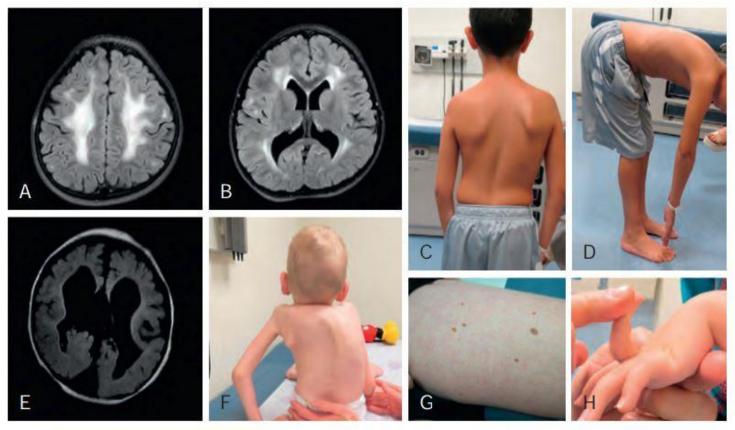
Findings in congenital muscular dystrophies. A and B, Axial FLAIR brain MRI images showing the increased T2 hyperintensity seen within the white matter in patients with LAMA2 CMD. C, Scapular winging and scoliosis in patient with SEPN1 muscular dystrophy. D, Rigid spine noted in forward flexion in patient with SEPN1 muscular dystrophy. E, Brain MRI in patient with muscle-eye-brain disease with absent corpus callosum, Dandy-Walker malformation, subependymal cysts. F, Early and severe kyphoscoliosis in a child with Ullrich congenital muscular dystrophy. G, Keratosis pilaris, a common skin finding in patients with collagen VI-related CMDs. H, Distal hyperlaxity seen in patients with collagen VI-related CMDs. (Courtesy Drs. Carsten Bönnemann and Reghan Foley, Neuromuscular and Neurogenetics Disorders of Childhood Section, NINDS/NIH.)
